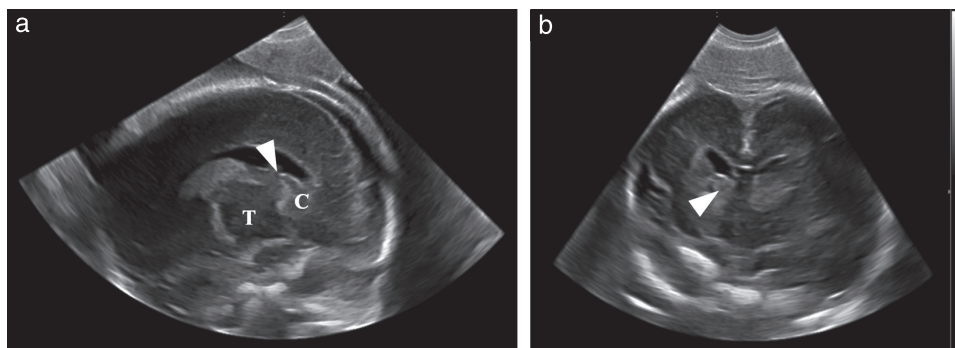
Three-dimensional ultrasound images at 24 weeks' gestation in fetus with *COL-4* mutation (Case 1), showing hemorrhage (arrowhead) of germinal matrix in parasagittal (a) and coronal (b) planes. C, nucleus caudatus; T, thalamus.
